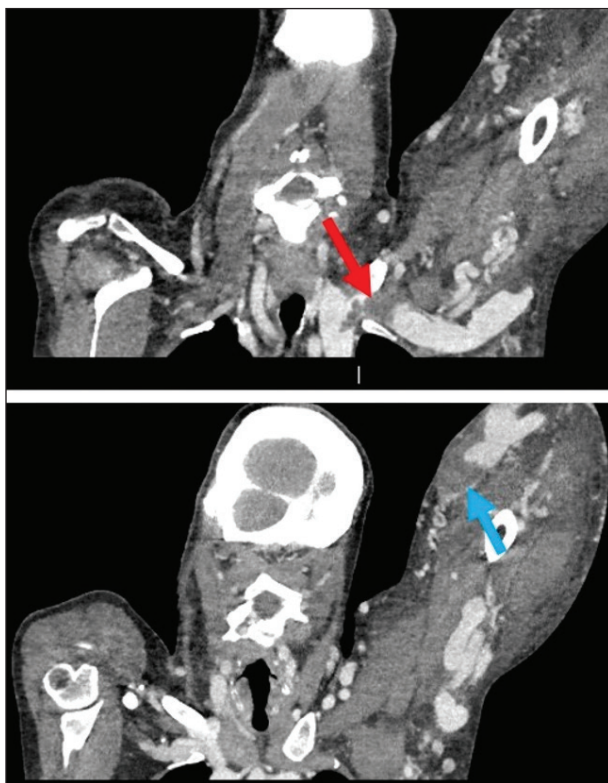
CT venogram (coronal reformat) demonstrating extensive occlusive thrombus in the left subclavian vein (red arrow) and cephalic vein (blue arrow) with dilated venous collaterals.
